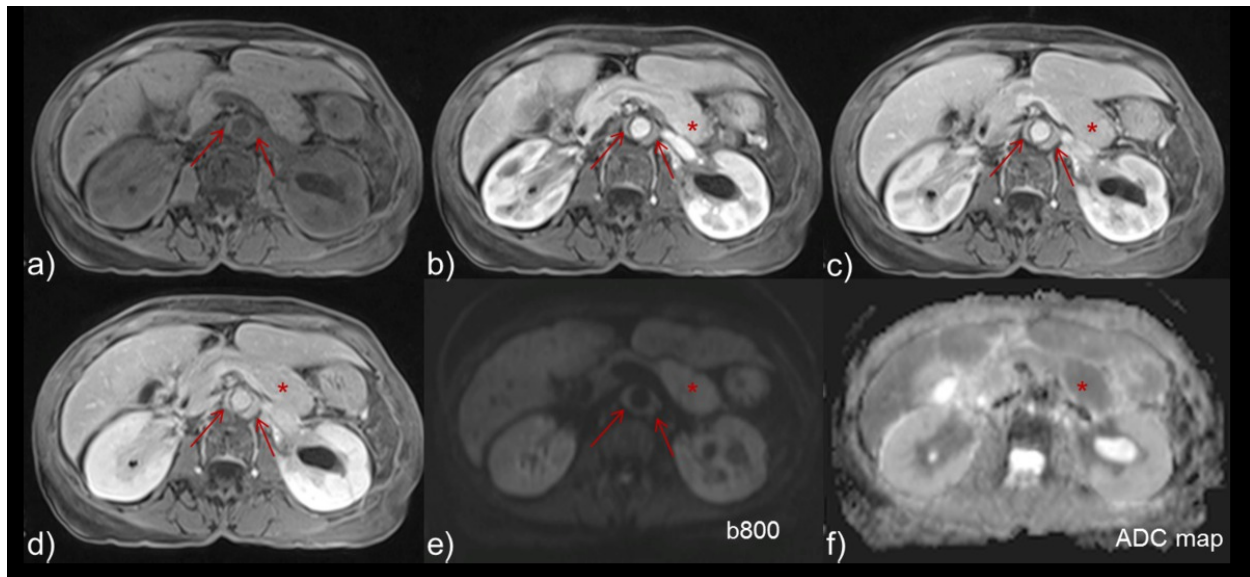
Axial T1 3D fat-saturation images a) b) c) d) axial DWI b-800 image e) and ADC map f) of a patient with focal enlargement in the pancreatic tail that was isointense and enhancing similarly with the remaining parenchyma, presenting with restricted diffusion and low ADC (*). A soft tissue lesion around the aorta was also seen with similar features to the pancreatic lesion (arrows); furthermore the left kidney presented dilatation of the cavities, and the soft-tissue lesion corresponded to retroperitoneal fibrosis, seen in about 10-20% of patients with autoimmune pancreatitis.
